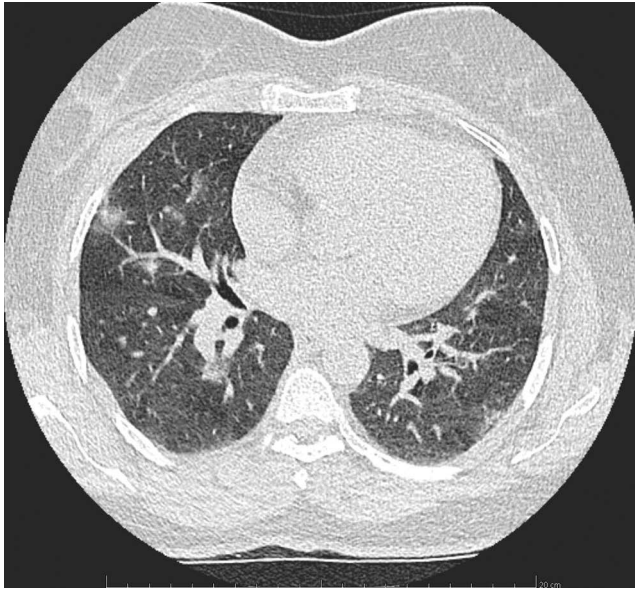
Trans axial Chest HRCT showed multiple bilateral ground-glass opacities (GGOs) with superimposed inter- and intralobular septal thickening, more located peripherally
